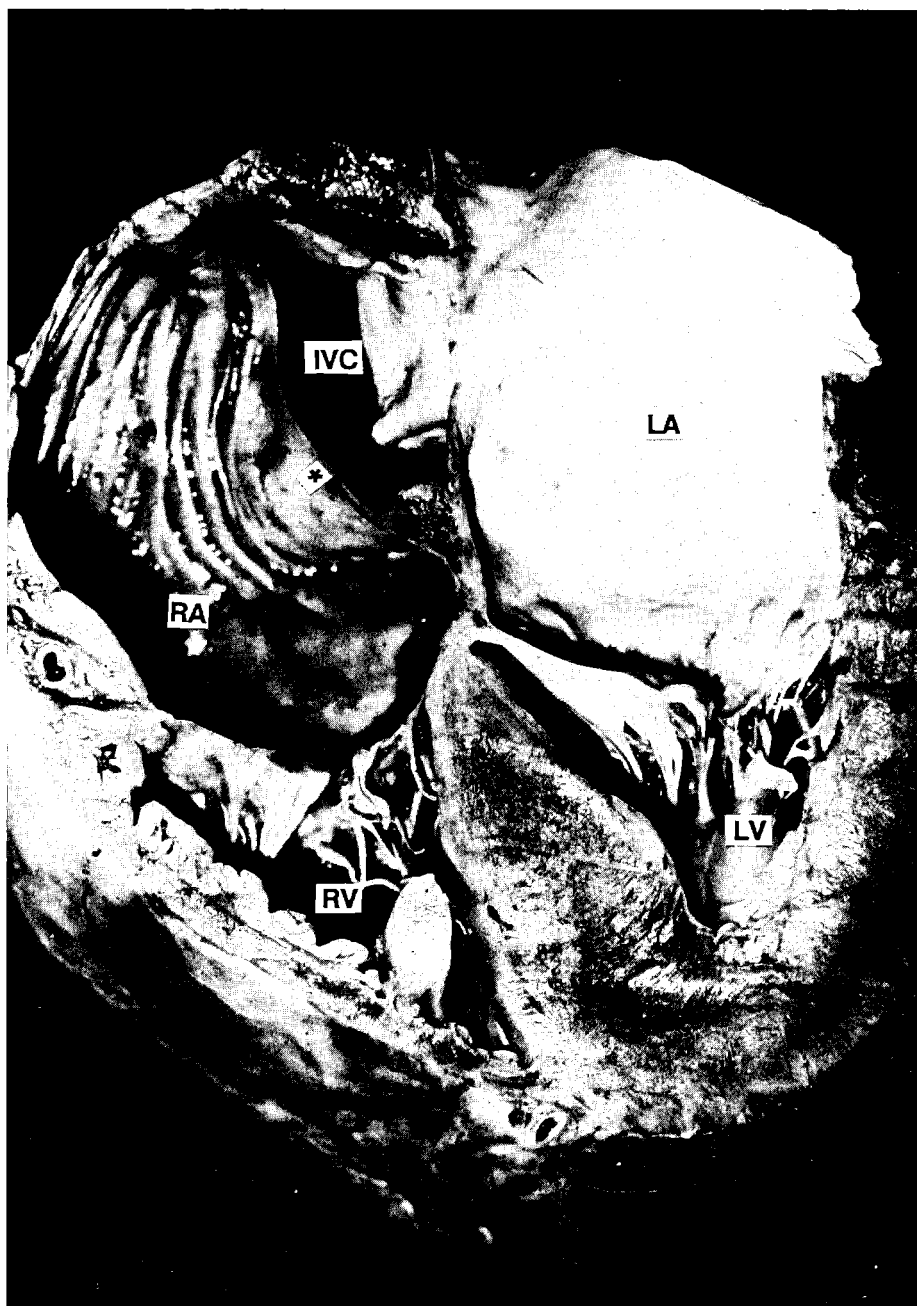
Anatomic correlate of a standard transoesophageal four-chamber view. The offsetting of both atrioventricular valves is nicely demonstrated as are their chordal attachments. Note the course and attachment of the Eustachian valve (asterix) to the atrial septum.
